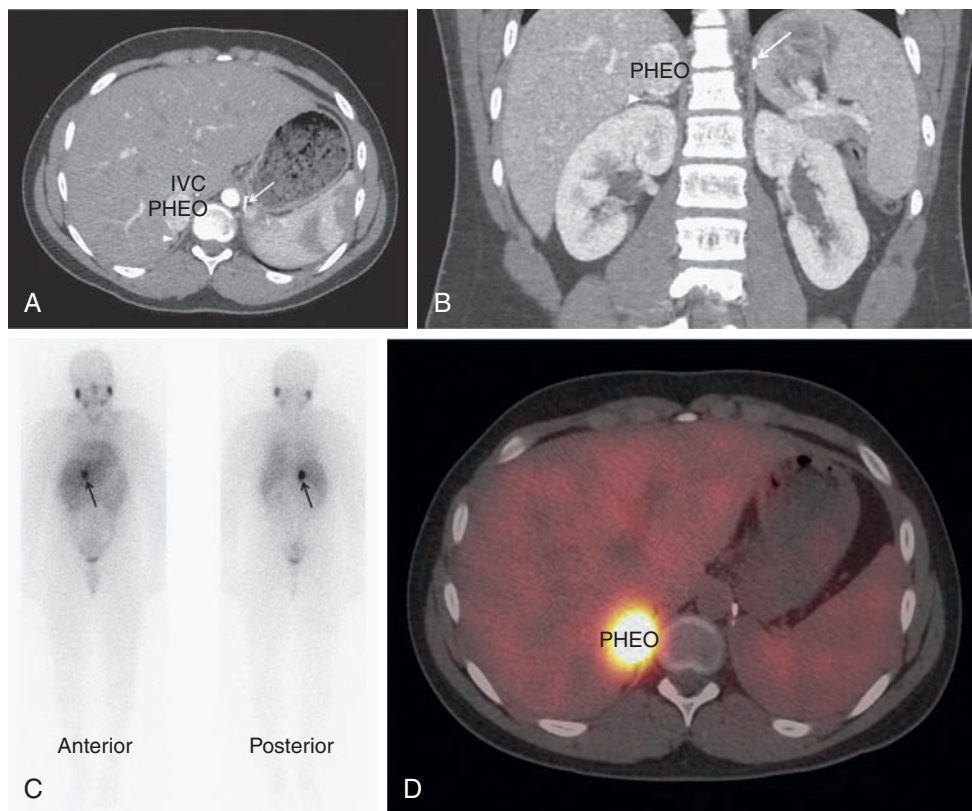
■ Pheochromocytoma. A normotensive 14-year-old male with von Hippel-Lindau disease and a history of a left pheochromocytoma and abdominal paraganglioma diagnosed at the age of 7 was found to have elevated norepinephrine and normetanephrine levels after screening with a 24-hour urine collection. Axial CT postcontrast (A) and coronal reconstruction (B) identified a vascular neoplasm (PHEO) arising from the superior right adrenal gland. IVC, inferior vena cava; arrowhead, normal adrenal gland; arrow, surgical clips from previous adrenalectomy. MIBG scan confirmed the functional nature of the tumor and ruled out other sites of disease. Planar (C) and fused SPECT/CT axial images (D) in the same patient, 24 hours after the administration of ¹²³I MIBG. (This image can be viewed in full color online at ExpertConsult.)
